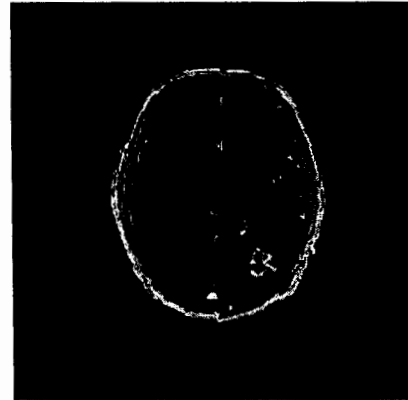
Fusion of CT and MR images of Brain by PCA
